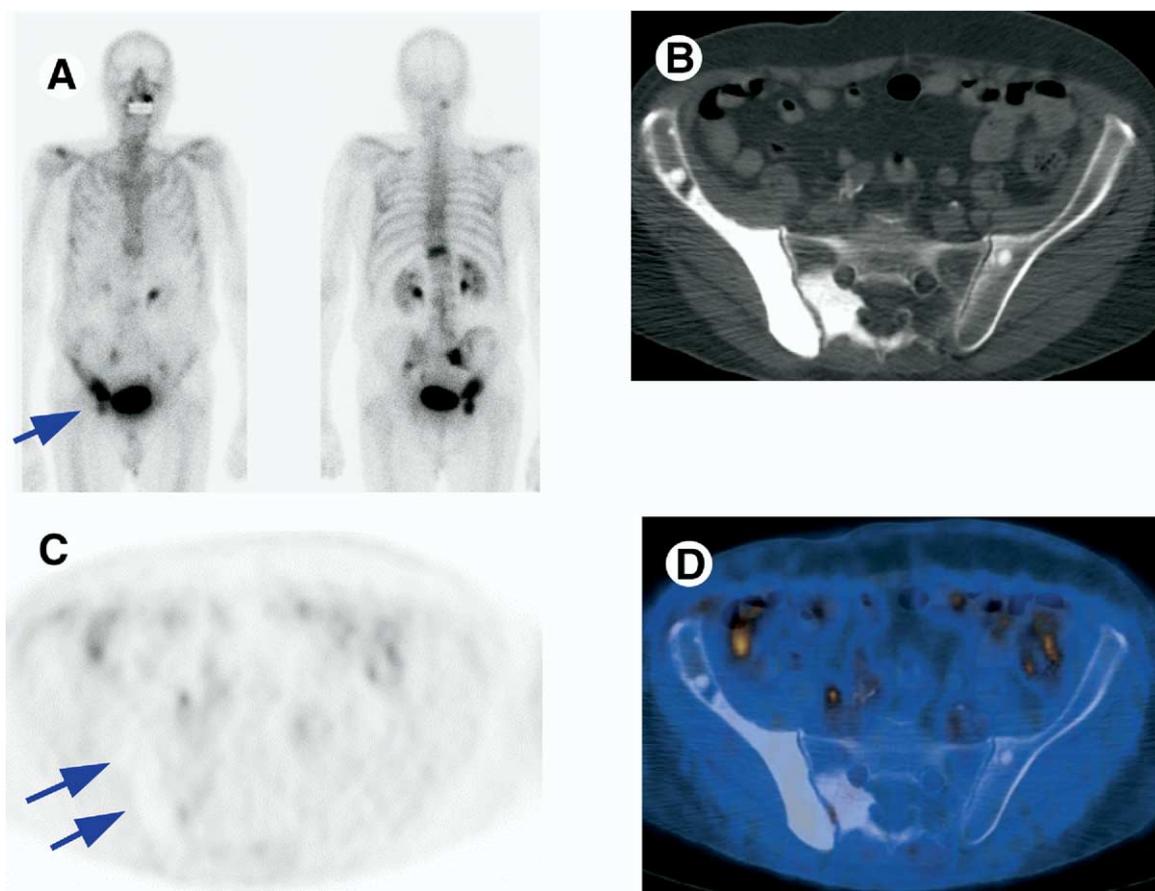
62-year-old male with osseous metastases from prostate cancer; PSA = 6.5 ng/mL. (A) Bone scan shows abnormal tracer uptake in the spine and pelvis. (B) CT, (C) PET, and (D) PET/CT fusion images of the pelvis. Note absence of FDG uptake in the sclerotic lesion in the right iliac bone, which shows intense tracer uptake on the bone scan. (Color version of figure is available online.)
